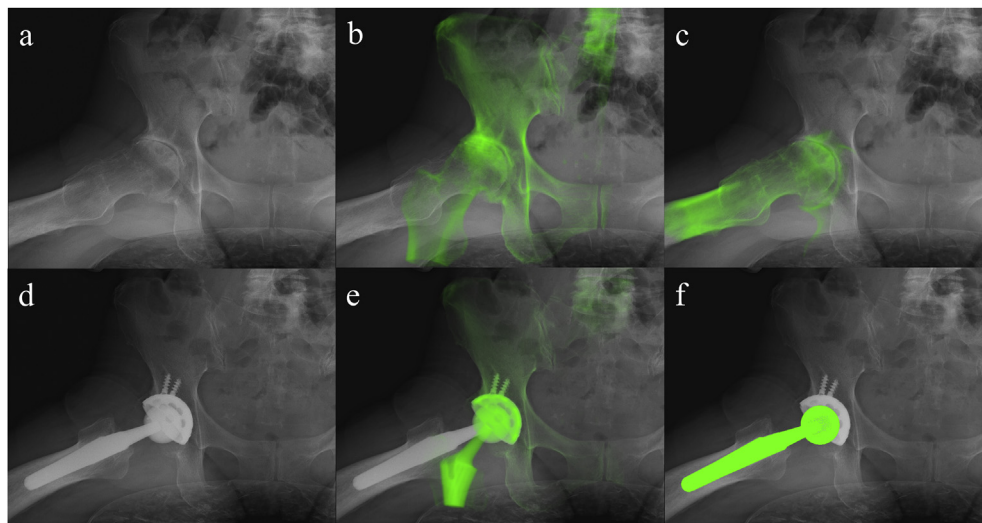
Hip motions during chair-rising before THA were captured as periodic radiographic images using a flat-panel detector (a). Digitally reconstructed radiographs of the pelvis (b) and femur (c) were compared with continuous radiographic images before THA. Replaced hip motions were also captured as periodic radiographic images using a flat-panel detector (d). Digitally reconstructed radiographs of the pelvis and acetabular cup (e) and projections of 3D computer-aided data of the femoral head and stem (f) were superimposed on 2D radiographic images.
